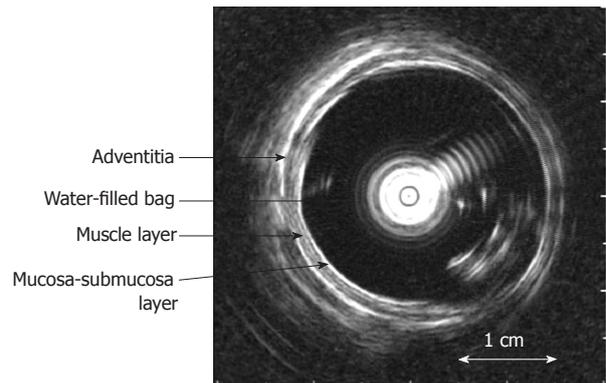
The cross-sectional ultrasound image of the distended distal esophagus allows identification of the esophageal layers, i.e. mucosa-submucosa, muscle and adventitia layers. The white round shadow in the centre is caused by the intraluminal ultrasound probe.
